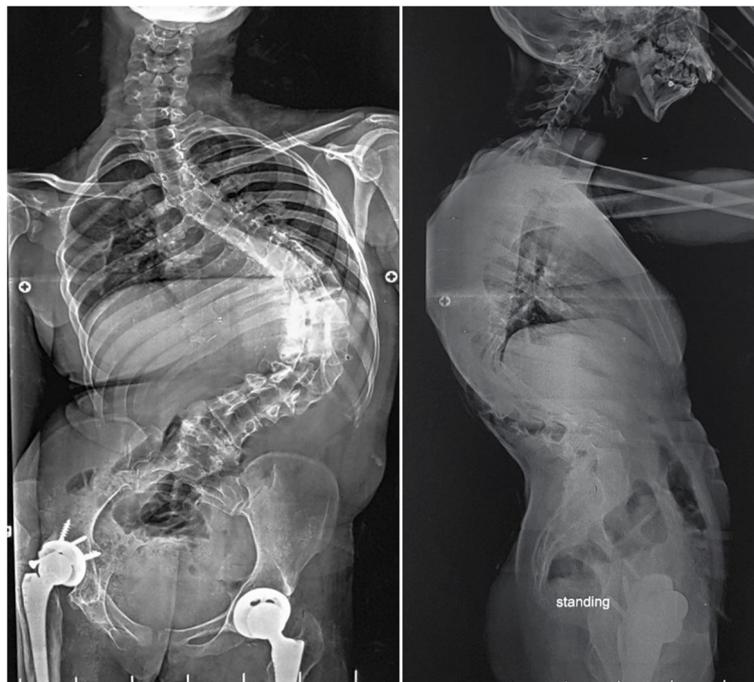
Final follow-up radiographs of the pelvis and the spine, showing the proper position of the total hip prosthesis, a progression of the spinal deformity, and preservation of the sacroiliac joints
